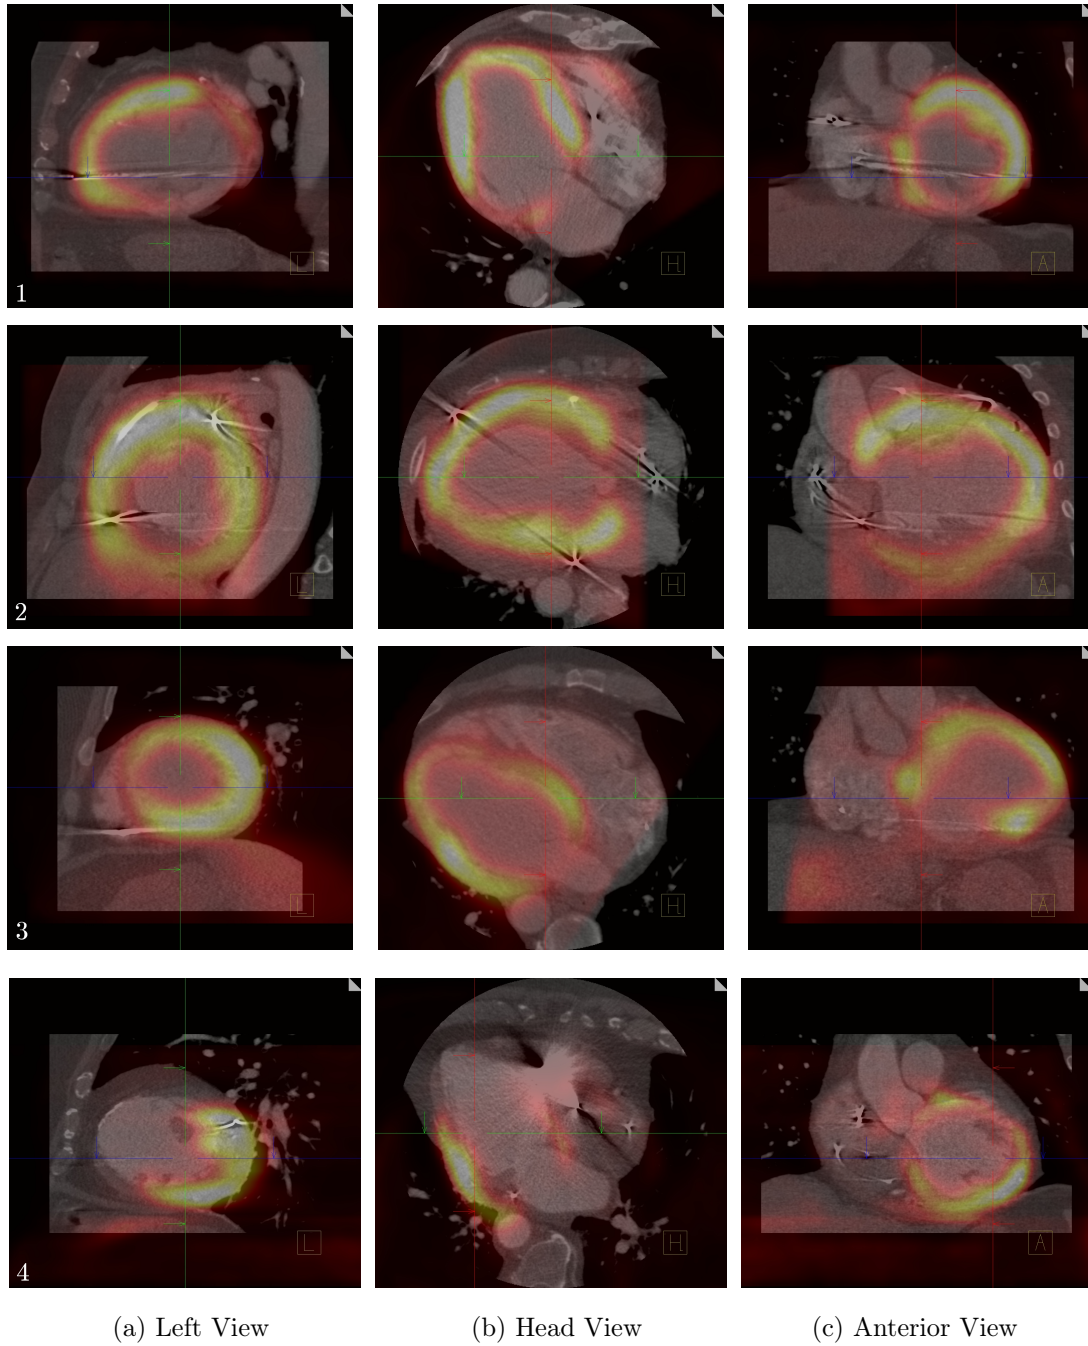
Three orthogonal views of registered and fused PET/CT data sets from four patients subject to VT ablation therapy. Registration is achieved by the integrated SIP model using a prior from patient three. Note the inherently challenging nature of the data, the reason why registration using NMI fails for all four data sets.
